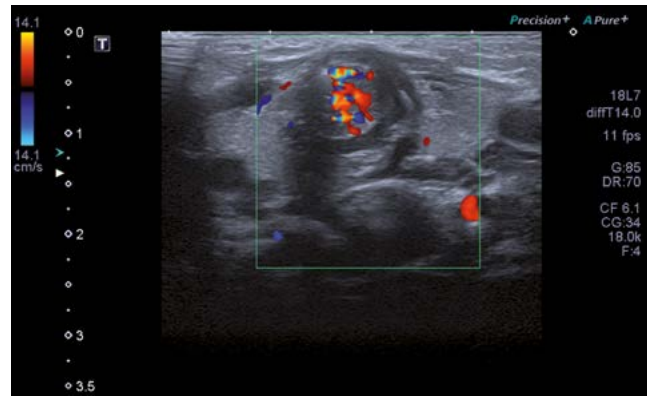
Color Doppler ultrasonography of the neck. Ultrasound imaging shows anterior displacement of the upper airway with lobular narrowing of the subglottic trachea. A measuring 7 x 7 mm is identified within the thyroid cartilage in the transverse plane, which appears markedly hypervascular on color Doppler.
